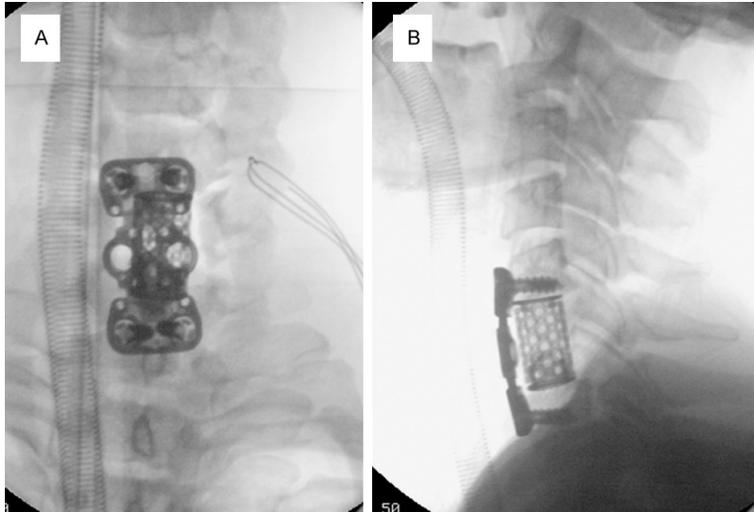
The anterior-posterior and lateral X-rays showed a good position of both the cages and the anterior plate.
